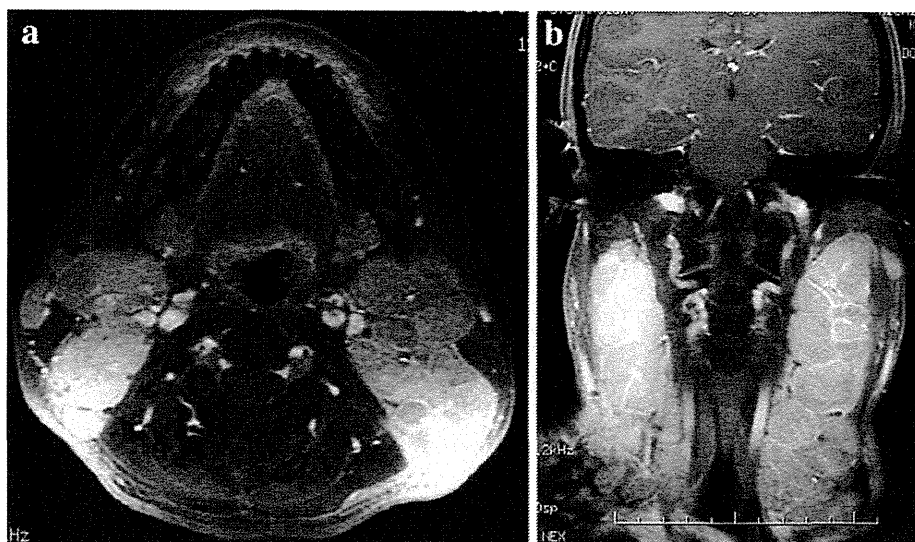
Contrast-enhanced MRI of the neck. Lymphadenopathy in both sides of the neck on an axial section (a) and a coronal section (b)
